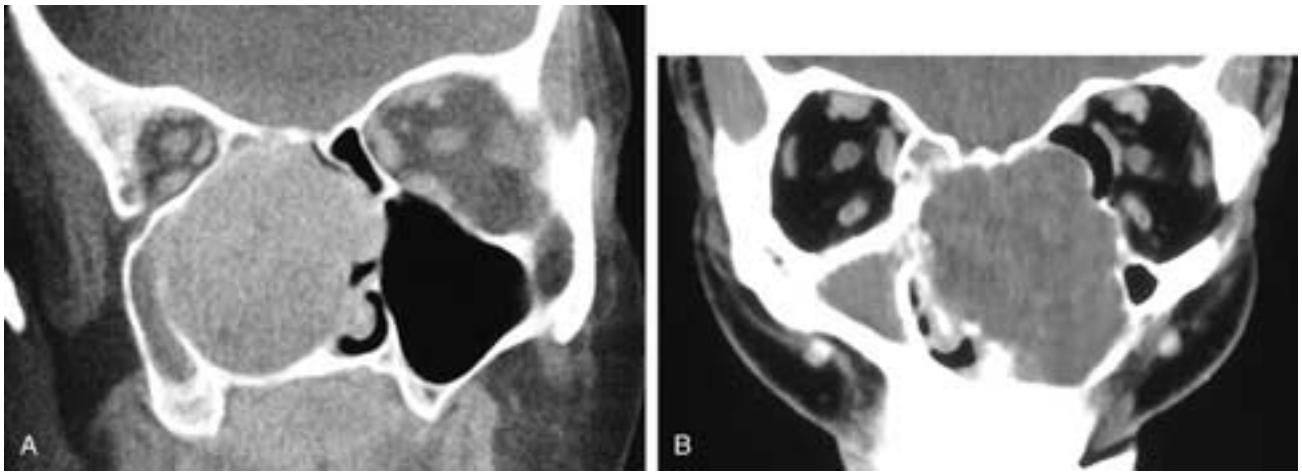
A, Coronal CT shows an expansile right nasal fossa mass that has remodeled most of the surrounding bone. It also has obstructed what remains of the right maxillary sinus. This patient had a low-grade mucoepidermoid carcinoma. B, Coronal CT scan on another patient shows a primarily expansile mass filling the nasal fossae and the left ethmoid and maxillary sinuses. The right antrum is obstructed by the mass. This patient had a low-grade mucoepidermoid carcinoma.
